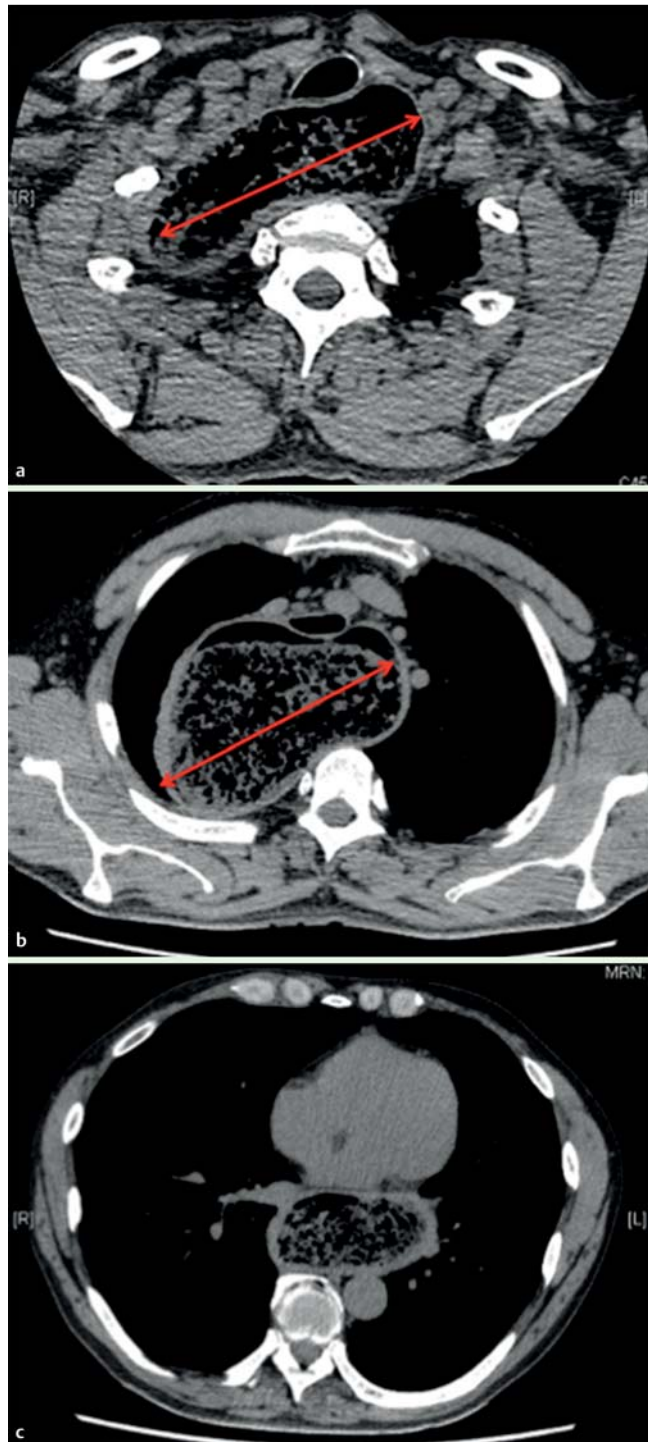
Computed tomography scan showing the esophageal dilation. a The 13 cm dilation (arrow) containing a large amount of residual food. b The same aspect in the middle third of the esophagus (arrow). c Dilation in the lower third of the esophagus.
